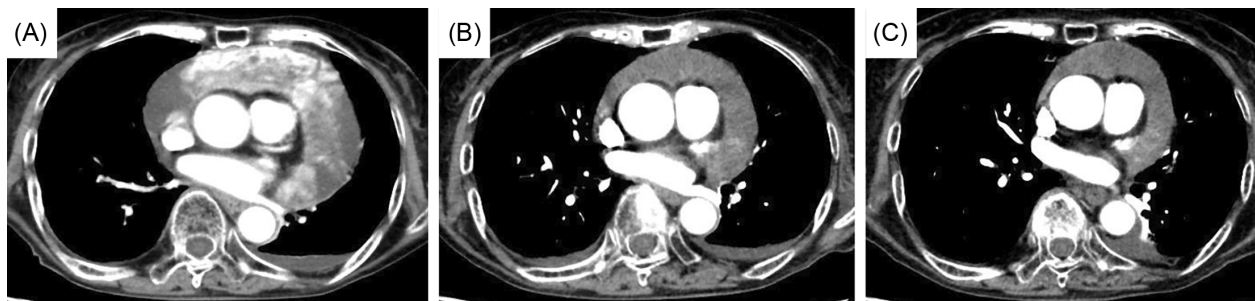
Contrast-enhanced chest computed tomography (CT) findings after treatment. The CT scans showed reduction in tumour size, pericardial effusion, and bilateral pleural effusion, respectively. (A) Chest CT on day 45. (B) Chest CT on day 122. (C) Chest CT on day 240.
